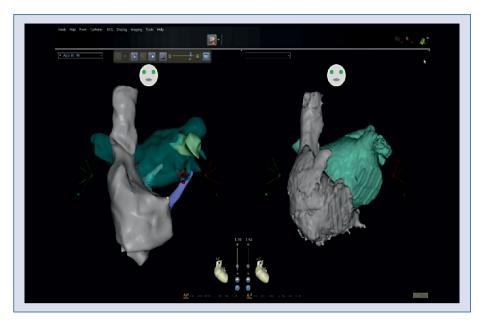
Left panel showing the three-dimensional electroanatomical CARTO maps (Biosense Webster, Diamond Bar, CA, USA) of right (gray) and left (green) atria with coronary sinus (blue) and right panel with three-dimensional reconstruction from magnetic resonance imaging. Both panels show the images from the anteroposterior view.
